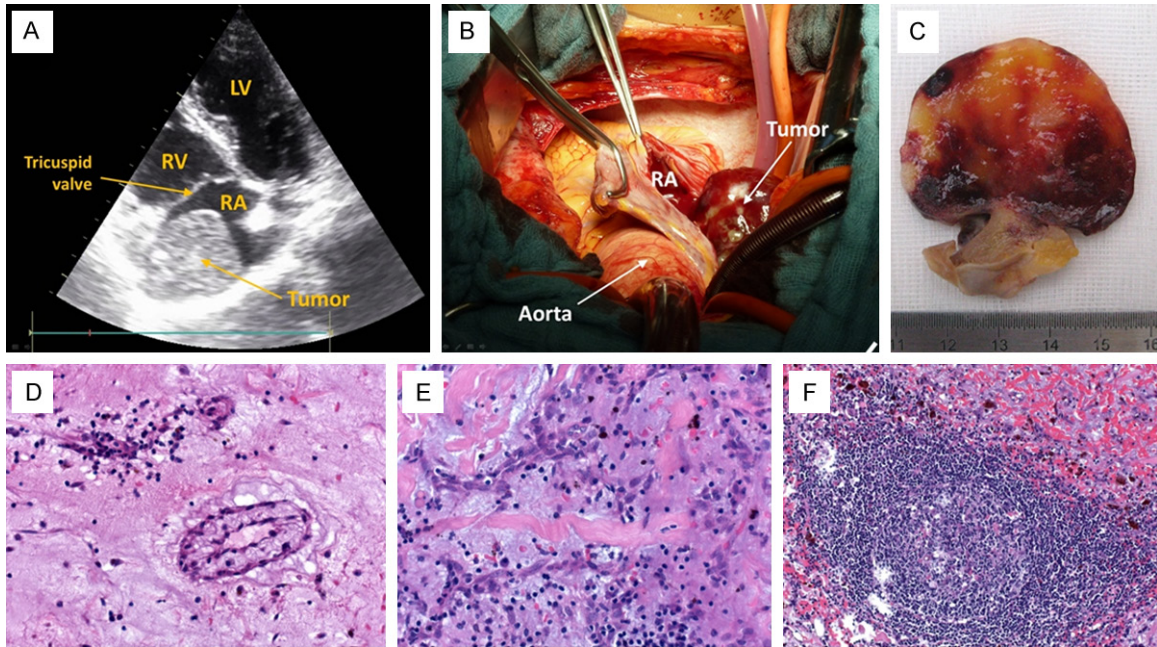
A: Transthoracic echocardiography revealed a large mobile mass (41 x 46 m) attached to the lateral wall of the right atrium. B: Intraoperative photograph showing the giant right atrial heterogeneous mass. The tumor also infiltrates parts of the inferior wall. C: Glistening cut surface of the tumor with predominantly deep red and sometimes pale yellow color. D: The tumor cells occasionally formed ring-like structures around primitive vessels. E: The macroscopically paler areas corresponded to heavily collagenized and inflamed stroma. F: Especially at the base of the tumor a prominent lymphofollicular reaction with admixed siderophages was seen.
